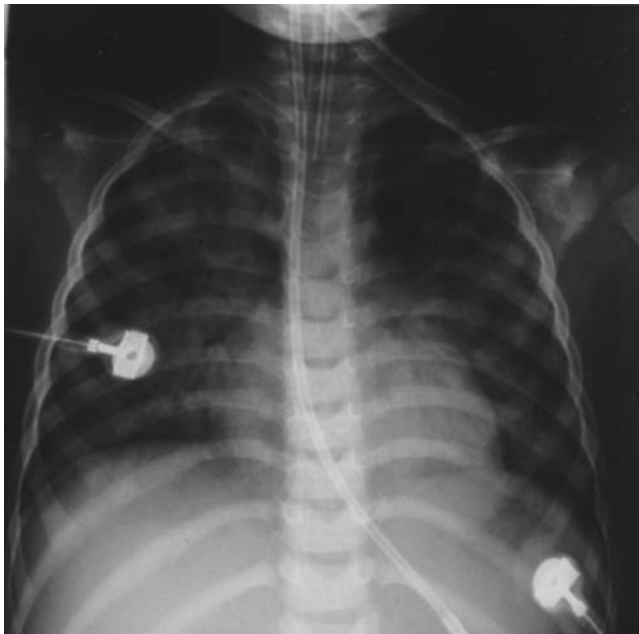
Chest radiographic findings in a young girl subsequent to lamp oil ingestion.
